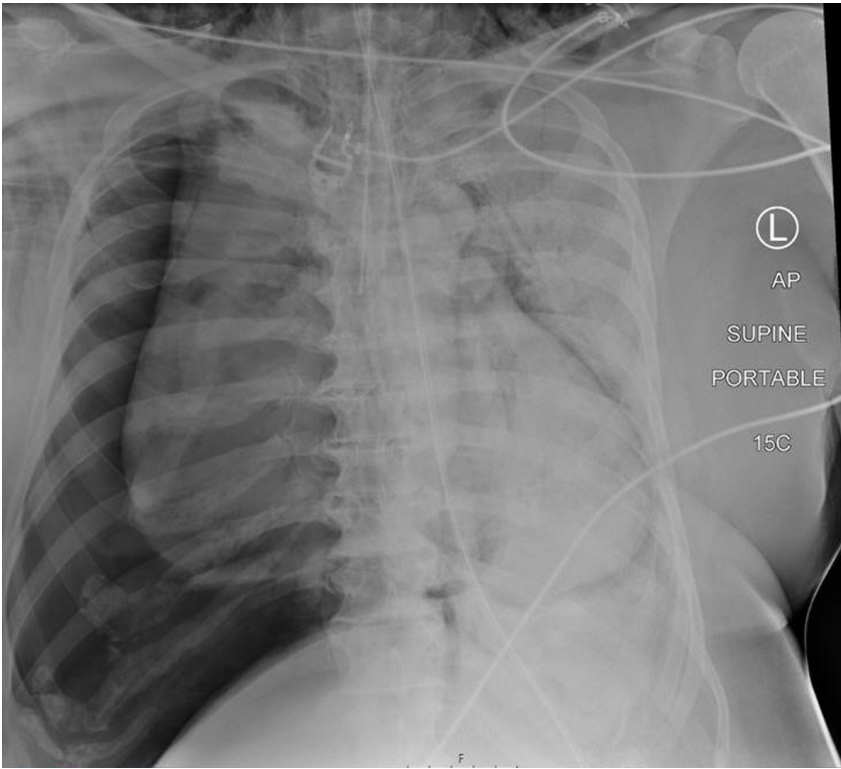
Chest radiograph (ordered prior to deterioration and completed simultaneous to drain insertion) showing right pneumothorax, displaced mediastinum and subcutaneous emphysema
